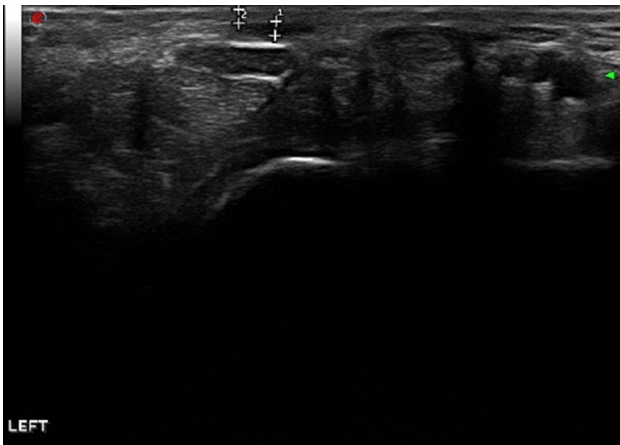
An ultrasonography image demonstrating (1) tendon thickness and (2) subcutaneous tissue thickness.
